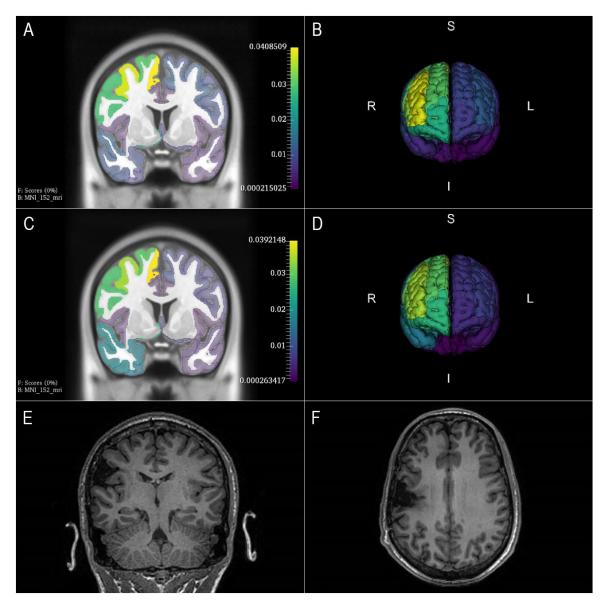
Example of Semiology Visualisation Tool. The top row demonstrates the epileptogenic zone prediction using initial semiology in coronal (A) and 3D (B) views. The middle row demonstrates the epileptogenic zone prediction using combined set-of-semiology in coronal (C) and 3D (D) views. The bottom row demonstrates the postoperative MRI in T1 coronal (E) and axial (F) views.
